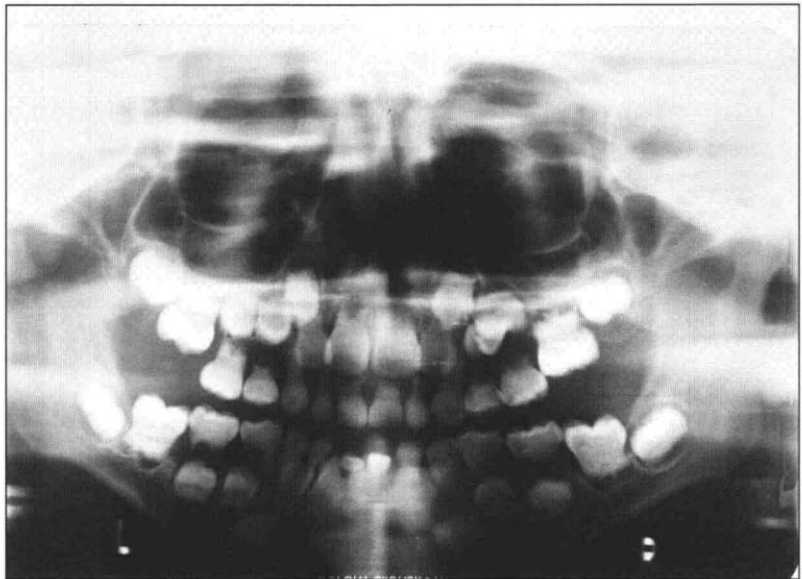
Panoramic radiograph of proband showing calcification and obliteration of all the dental pulps including those of the developing teeth. Note horizontal radiolucent lines approximately parallel to the cemento-enamel junctions and the large periapical radiolucencies around the resorbed roots of the primary molars.
